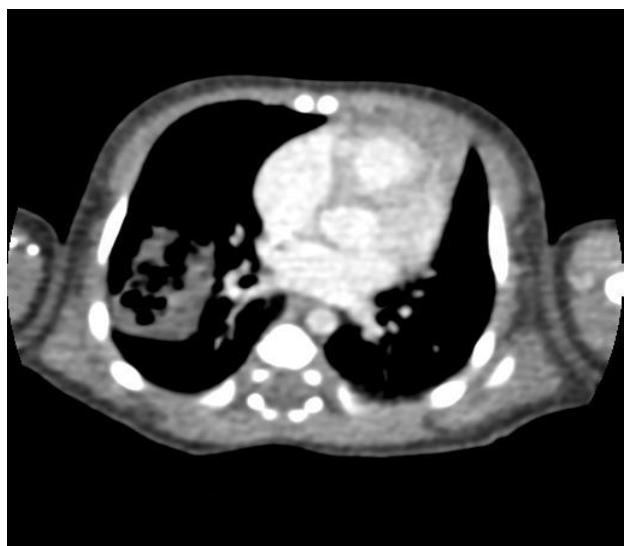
Axial contrast-enhanced HRCT image showing better delineation of the cystic components and their relationship to adjacent vascular structures.
